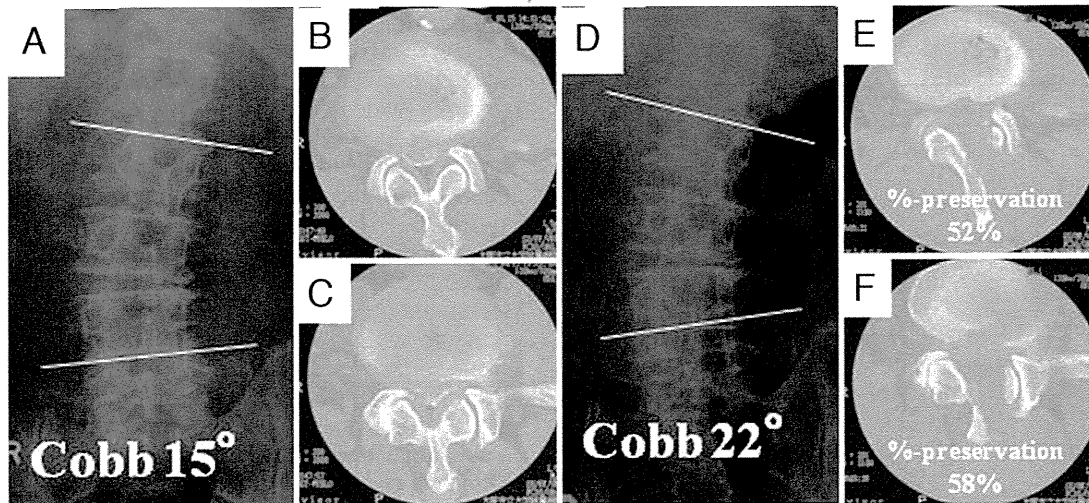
Imaging studies acquired in a 71-year-old man who underwent MBDU on the concave side. Preoperative standing AP radiograph (A), preoperative axial CT images at L3–4 (B) and L4–5 (C). The spinous processes are inclined to the approach side, giving a narrower view from the concave side. Postoperative AP radiograph (D) acquired 2 years postoperatively demonstrating obvious postoperative spinal instability. Postoperative axial CT images at L3–4 (E) and L4–5 (F) showing poor preservation of the facet joints (percentage of facet preservation on the approach side: L3–4, 52%; L4–5, 58%).
